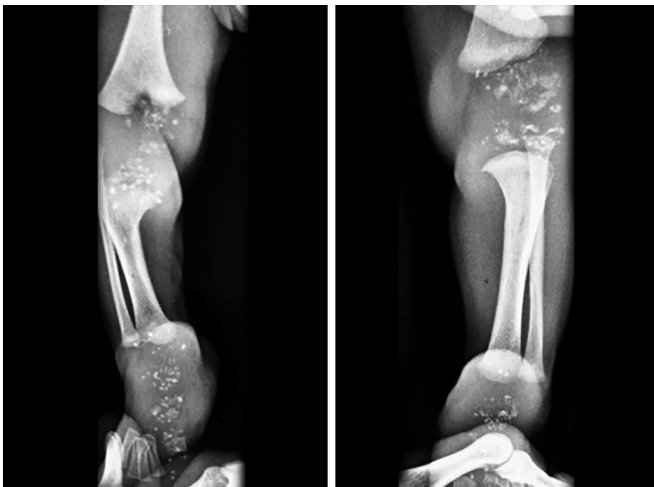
X-ray of lower limb showing calcific stippling of epiphyses of knee and ankle joints characteristic of Chondrodysplasia punctata.
